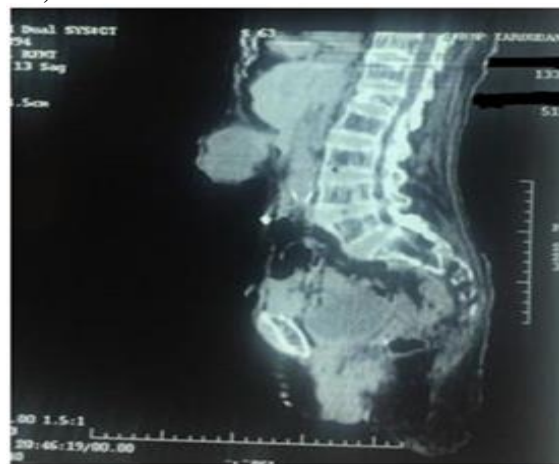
CT scan sagittal view with intravenous injection contrast; showing a voluminous mass of the gall bladder; with fistulization of the anterior abdominal wall and located in front of the lumbar vertebra L3.
